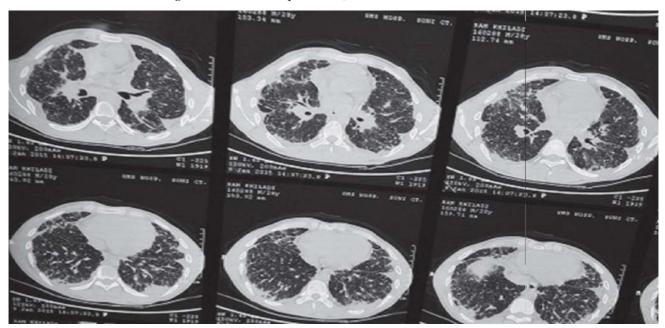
Contrast enhanced computed tomography of chest showing bilateral pleural thickening, septal thickening and groundglass opacity in lower lobes.
